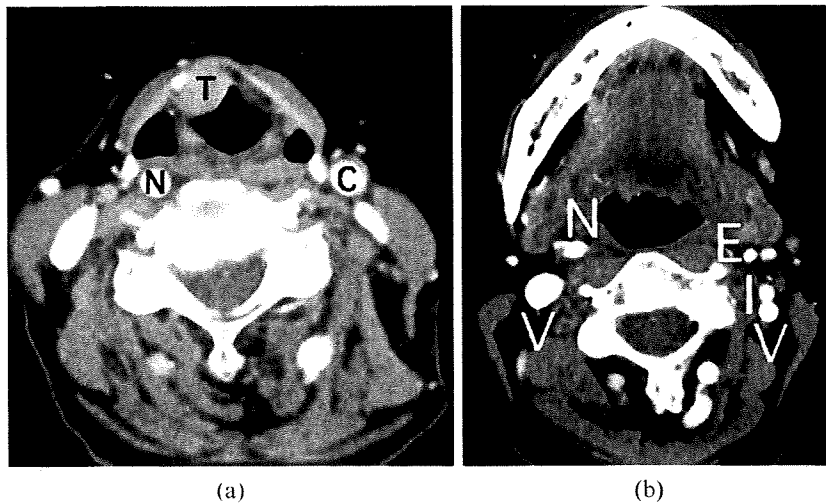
CT scan with contrast enhancement at (a) the level of the middle of the thyroid cartilage showing a relatively median location of the right non-bifurcating carotid artery (N) compared with that of the left common carotid artery (C), and (b) at the level of the tip of the epiglottis showing the right non-bifurcating carotid artery (N) with a divided branch compared with a division into the internal carotid artery (I) and the external carotid artery (E) on the left side. T, upper part of the supraglottic tumour; V, internal jugular vein.
